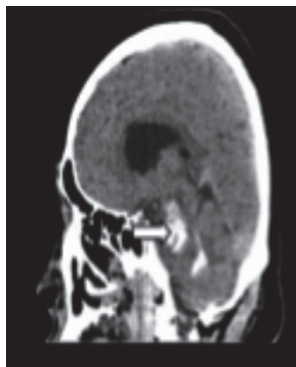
(B): Sagittal Plain CT Brain Image Showing the Midbrain
